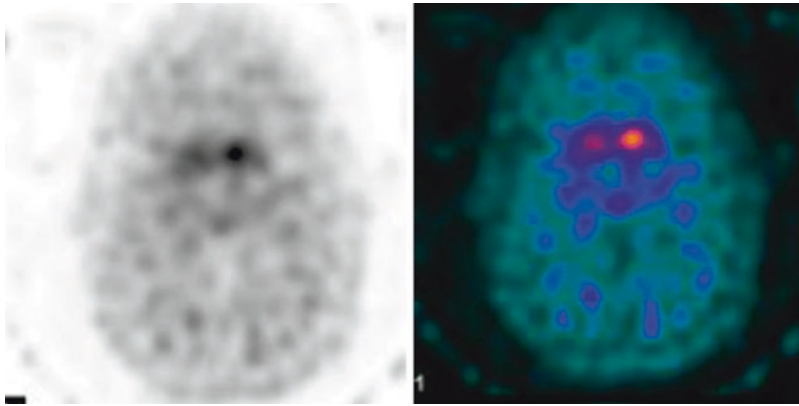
Abnormal ^{123}I -FP-CIT SPECT. Patient is a 54-year-old female with movement disorders and Parkinson's disease. Scan being performed to assess for integrity of the nigrostriatal pathway. There is absence of uptake in the putamen both on the right and the left. There
